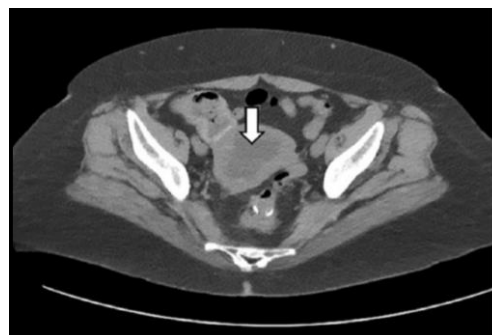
CT PELVIS showing a hypoechoic lesion (white down arrow) within the endometrial cavity
